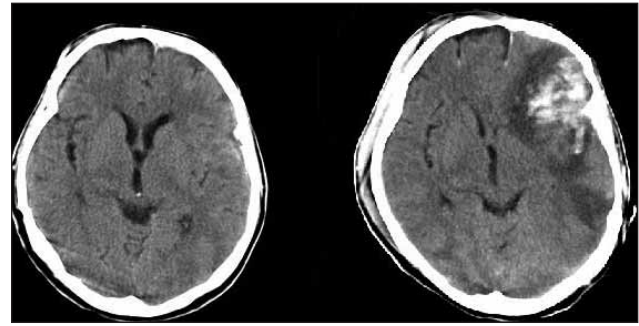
Cranial CTs of a patient with a WBC count of $22.5 \times 10^6/l$ showing CT progression.
